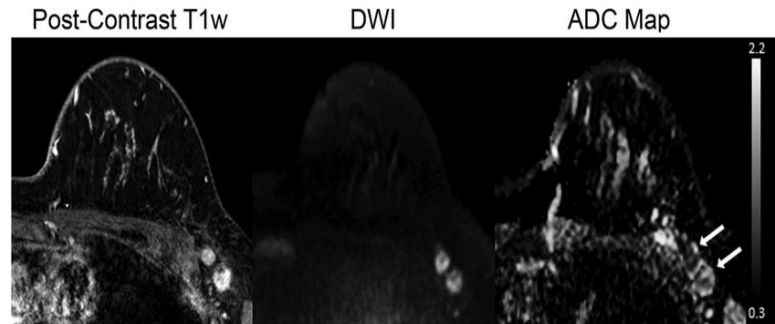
In this case of axillary lymph node metastasis of invasive ductal carcinoma in her left breast. The MRI revealed few abnormal axillary lymph nodes, which were confirmed to be infiltrated by cancer cells upon biopsy. These lymph nodes exhibited enhancement on post-contrast T1-weighted images and hyperintense signal intensity on diffusion-weighted imaging (DWI) with a b-value of 1000 s/mm², indicative of restricted diffusion. Additionally, the apparent diffusion coefficient (ADC) map showed low values, measuring $0.83 \times 10^{-3} \text{ mm}^2/\text{s}$ for the anterior lymph nodes and $1.17 \times 10^{-3} \text{ mm}^2/\text{s}$ for the posterior lymph nodes (indicated by arrows).⁽¹⁸⁾
